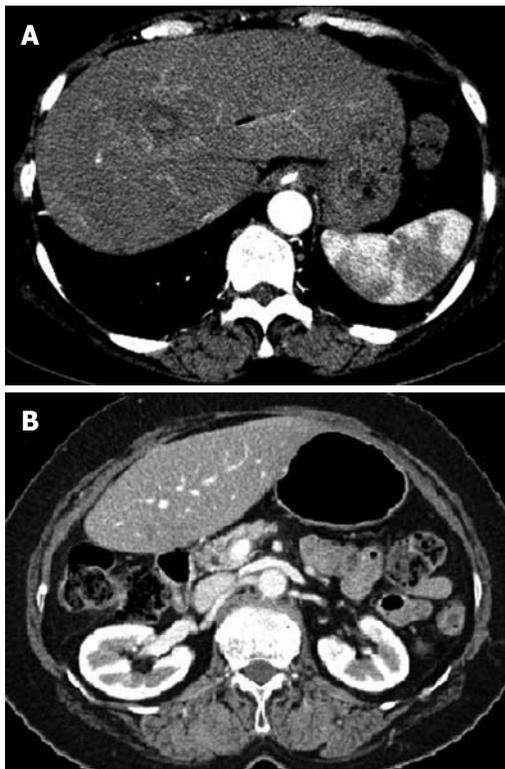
Follow-up of abdominal computed tomography scans 3 mo later showed that both previously noted hepatic artery pseudoaneurysm in the left lateral segment (A) and diffuse swelling and infiltration of pancreas (B) had disappeared.
